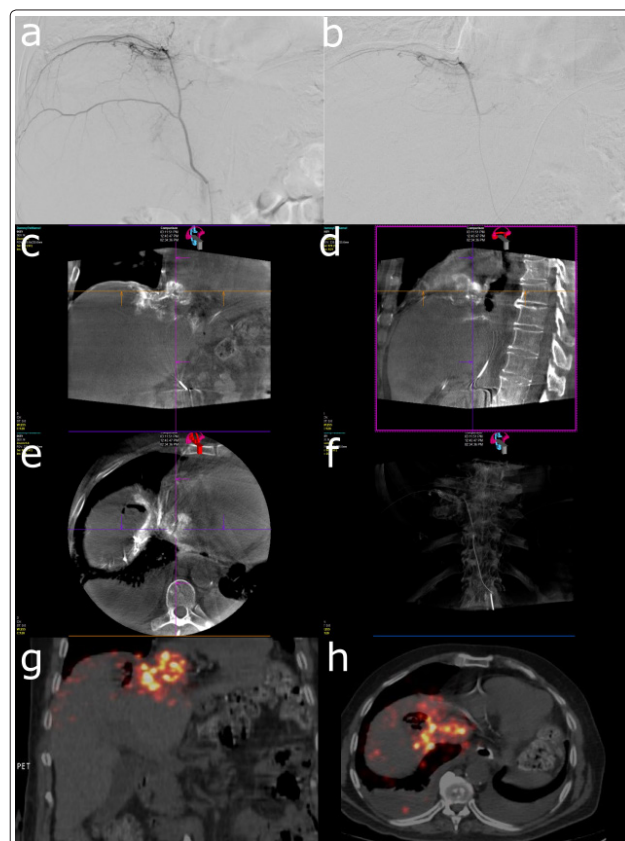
Pre-injection DSA (a-b) and Cone-beam CT c-f) show contrast uptake of the tumor and diaphragm through Right inferior phrenic artery (rIPA). Contrast media was injected through a 2.7 Fr microcatheter advanced beyond the posterior branch of the IPA to avoid radiation to the posterior half of the right hemidiaphragm. Dose uptake in the tumor and diaphragm was evaluated on post-treatment 90Y-PET-CT images (g-h).
